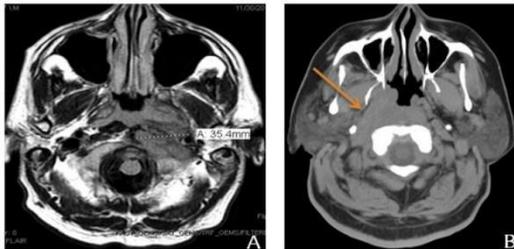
Stage IV Nasopharyngeal carcinoma on MRI [19]
